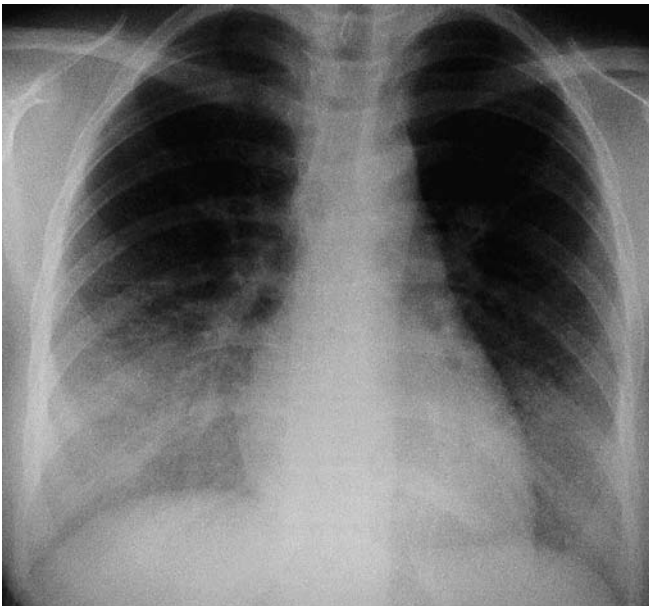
Patient's chest roentgenogram after one course of pulsed steroid therapy. Alveolar interstitial infiltrates are present in the bilateral pulmonary lower lobe
